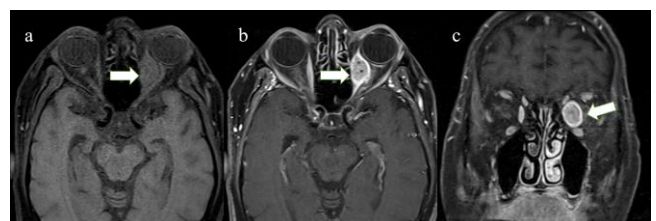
Axial pre-contrast (a) and postcontrast (b) with coronal post-contrast (c) fat-saturated T1-weighted fast-spin echo images showing a mass with contrast enhancement in the belly of the left medial rectus muscle, Case 1
